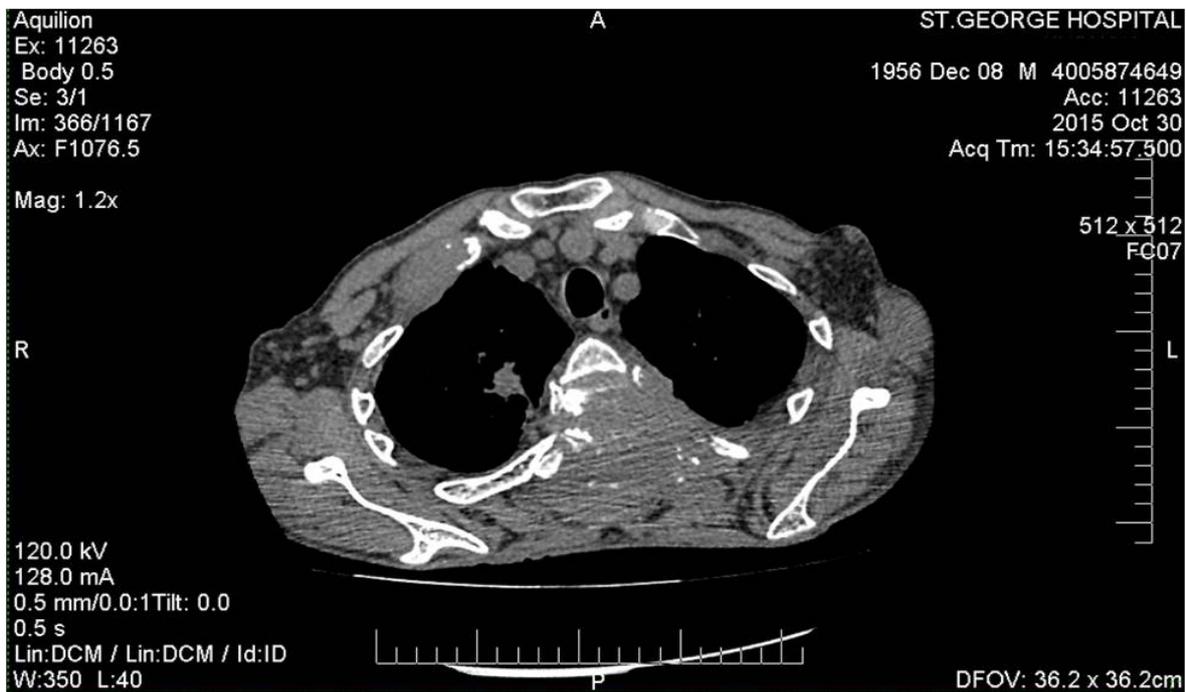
Chest computed tomography scan. Osteolytic destruction in the bodies and spinous processes of thoracic vertebra and soft-tissue involvement.
